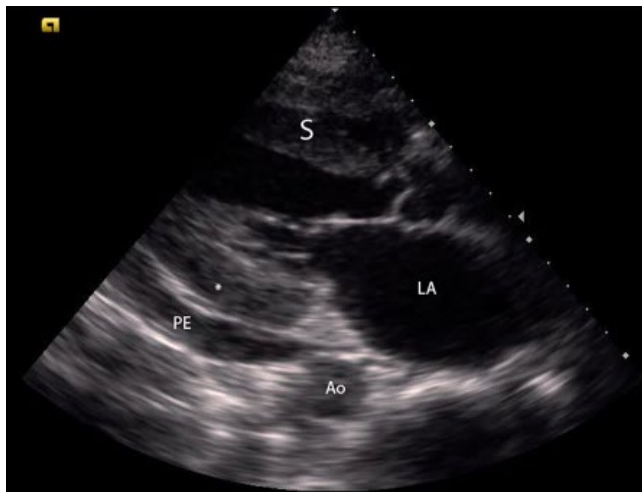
Parasternal long axis view showing a pericardial effusion (PE) characteristically tapering anterior to the descending aorta (Ao). Image from Video 33.3. S, septum; LA, left atrium; *, left ventricular free wall.
